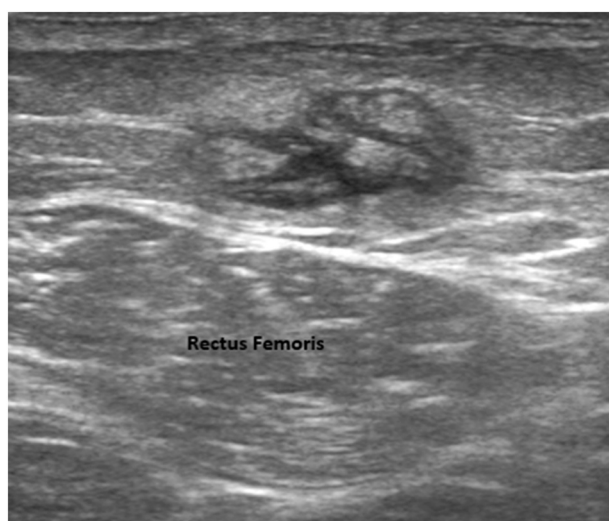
Ultrasonography of isoechoic mass in subcutaneous level sized $1.76 \times 2.02 \times 0.8$ cm, formed by small multiple nodules and hypoechoic fluid. Rectus Femoris muscle is depicted underneath the mass.
